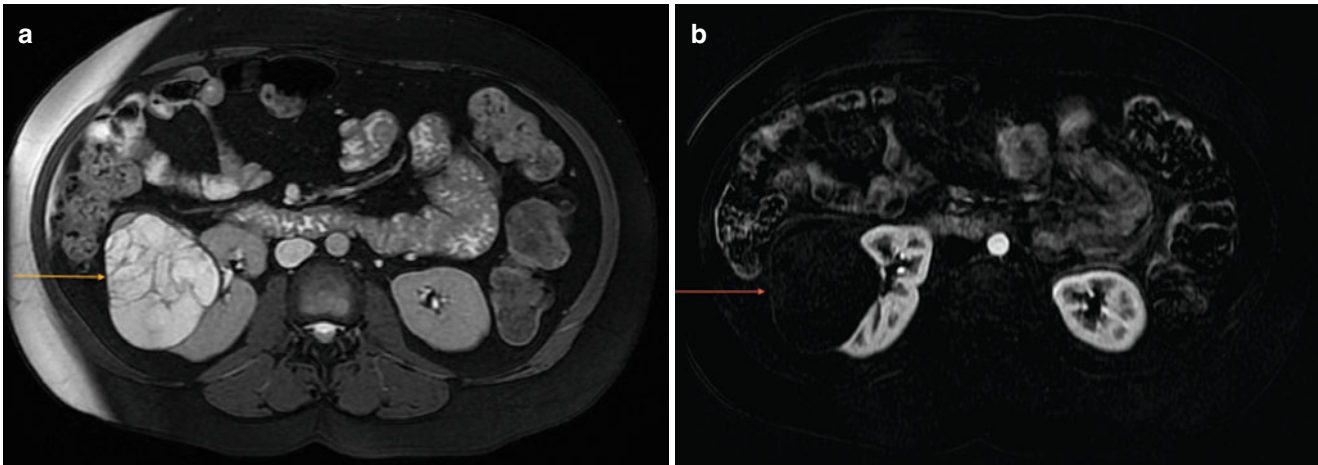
Complex cystic renal mass. Axial T2-weighted (a) MRI image demonstrates a cystic right renal mass with numerous septations of varying thickness (*orange arrow (a)*). Contrast-enhanced subtraction image (b) shows the lack of enhancement within the wall of the mass or any of the septations (*arrow (b)*). The numerous septations in this mass
